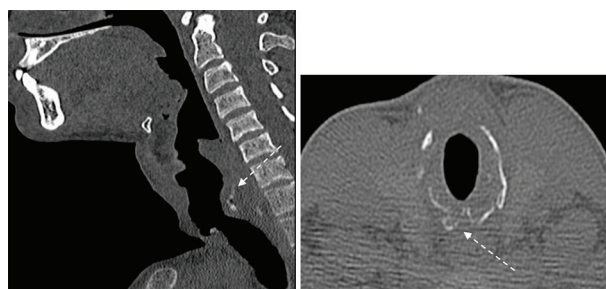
Location of cartilage graft (CT picture after 1 year)
